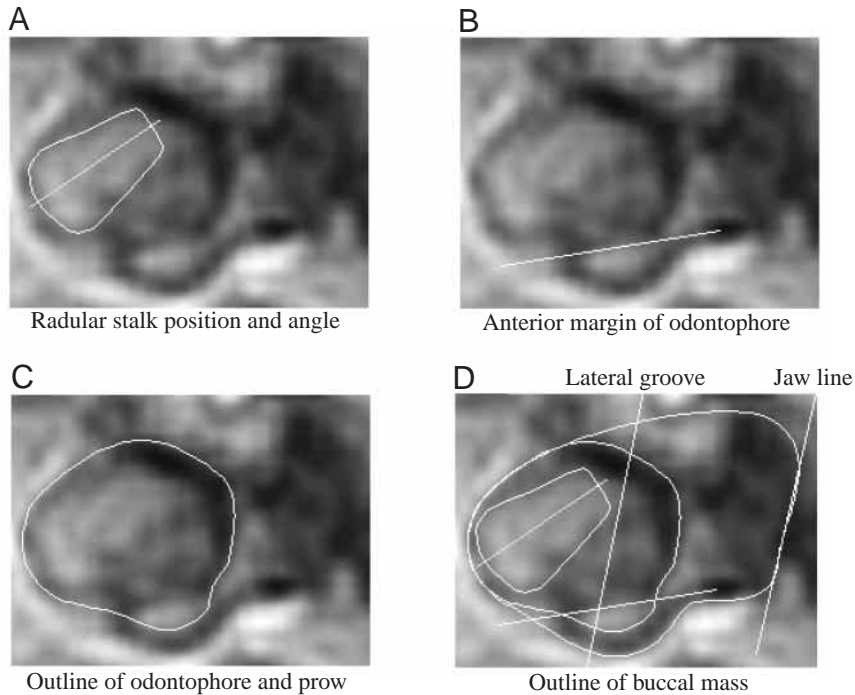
Measurements on high-temporal-resolution magnetic resonance images. The same image is shown in A–D. (A) Radular stalk outline (see Fig. 3 and text) and a line indicating the axis of the radular stalk. (B) The angle of the anterior margin of the odontophore, determined by the margin of the I6 muscle just posterior to the prow (see Fig. 6 and text). (C) Outline of the odontophore including the prow. (D) Image showing all the measurements shown in A–C and, in addition, an outline of the entire buccal mass (excluding the pharyngeal tissue), the line of the jaws and the line of the lateral groove (the dorsal and ventral border between the I1/I3/jaw musculature and the posterior I2 muscle).
